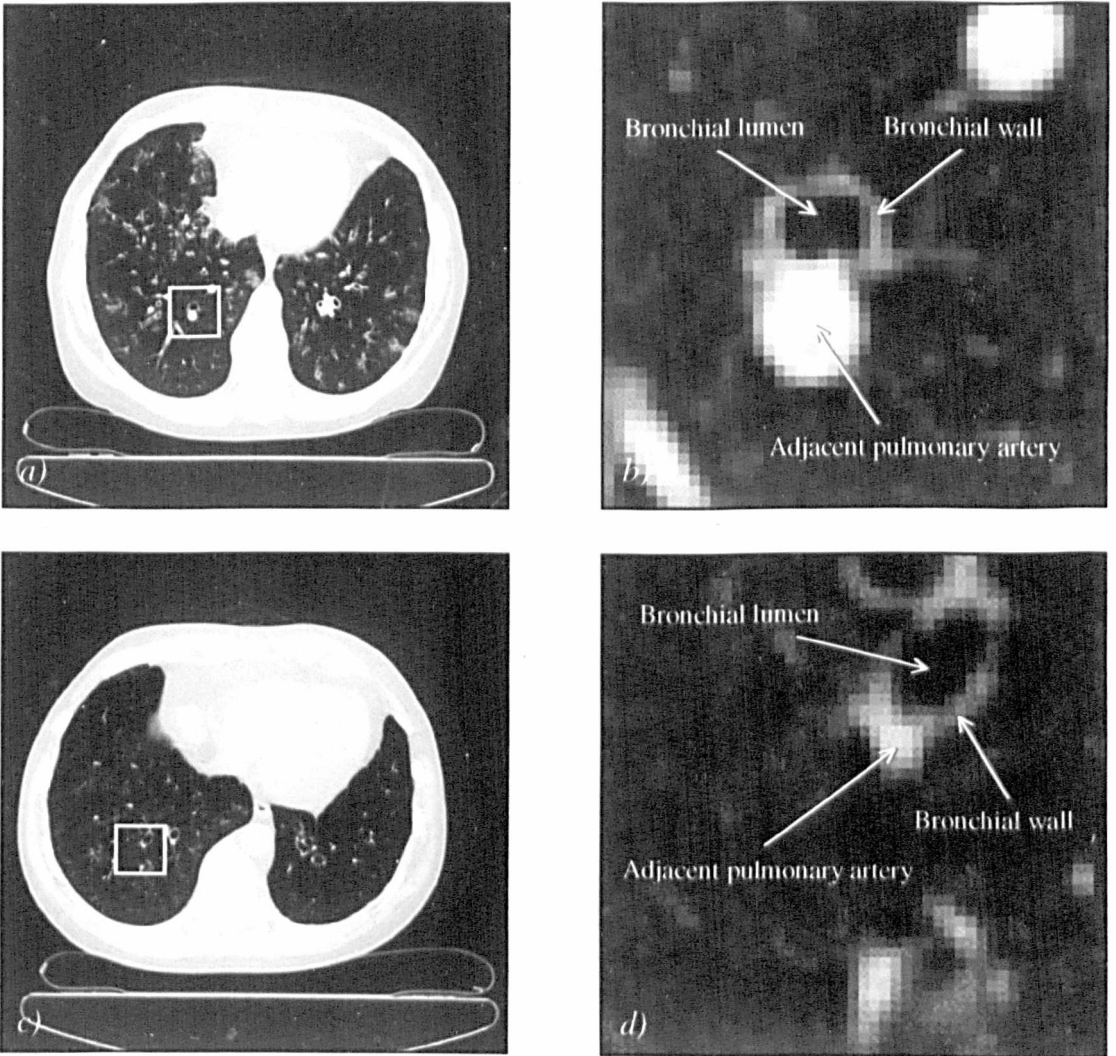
a)* HRCT of the chest (window settings: level = -500 H.U., width = 1500 H.U.). A major bronchovascular bundle nearly perpendicular to the plane of acquisition is highlighted with a white square. *b)* Enlarged view of the bronchus highlighted in Figure (1.8a). The bronchial wall appears as a bright elliptical ring. Detecting bronchial abnormalities is achieved by comparing the radius and thickness of the bronchus to the radius of the adjacent pulmonary artery. Here, the radius of the bronchus is roughly equal to the radius of the artery, demonstrating normal bronchial morphology. Using this criterion, other bronchi on this section can be seen to be abnormally dilated. *c)* HRCT of the chest showing severe bronchial abnormalities. *d)* Enlarged view of the bronchus highlighted in Figure (1.8c). The bronchus does not run exactly perpendicular to the plane of acquisition, and appears elliptical. Nevertheless, it may be assessed by an experienced radiologist for diagnostic purposes. The ratio of bronchovascular diameters is greater than 2, indicating bronchiectasis.
